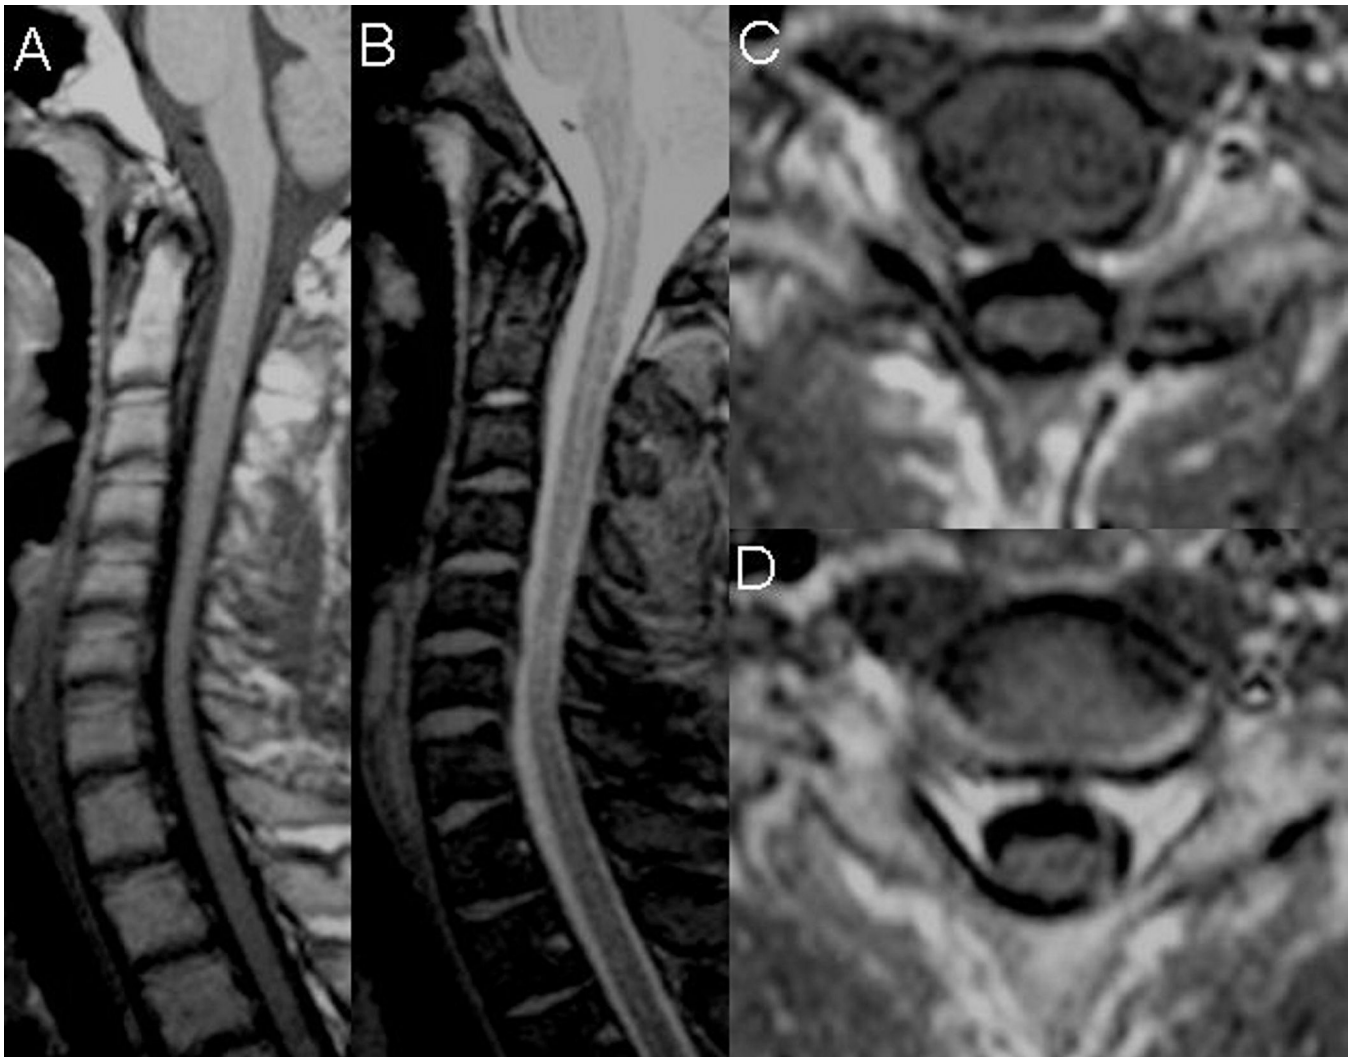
Cervical MRI of patient 4 in neutral neck position
